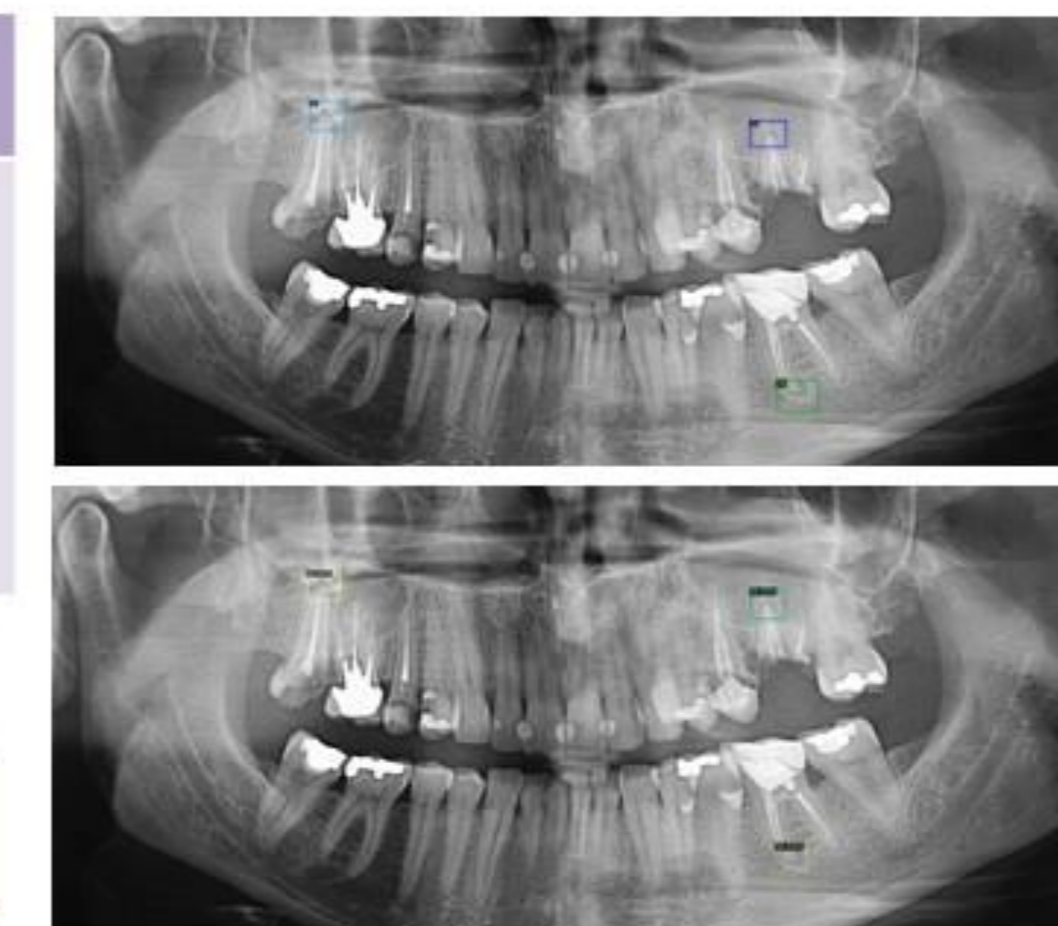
Example of the detected periapical lesions. First: Groundtruth, Second: AI Output
